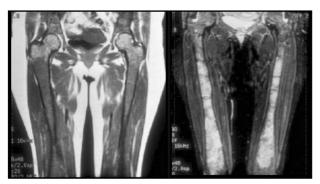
Fig. 35 year old male with Type I Gaucher disease MRI of both thighs MRI of the thighs: A) T1 WI (TR/TE 400/16) B) T2 WI (TR/TE 5000/68) Diffuse decreased SI involves the medullary cavity on T1 WI (A) that became higher on T2 WI (B)
